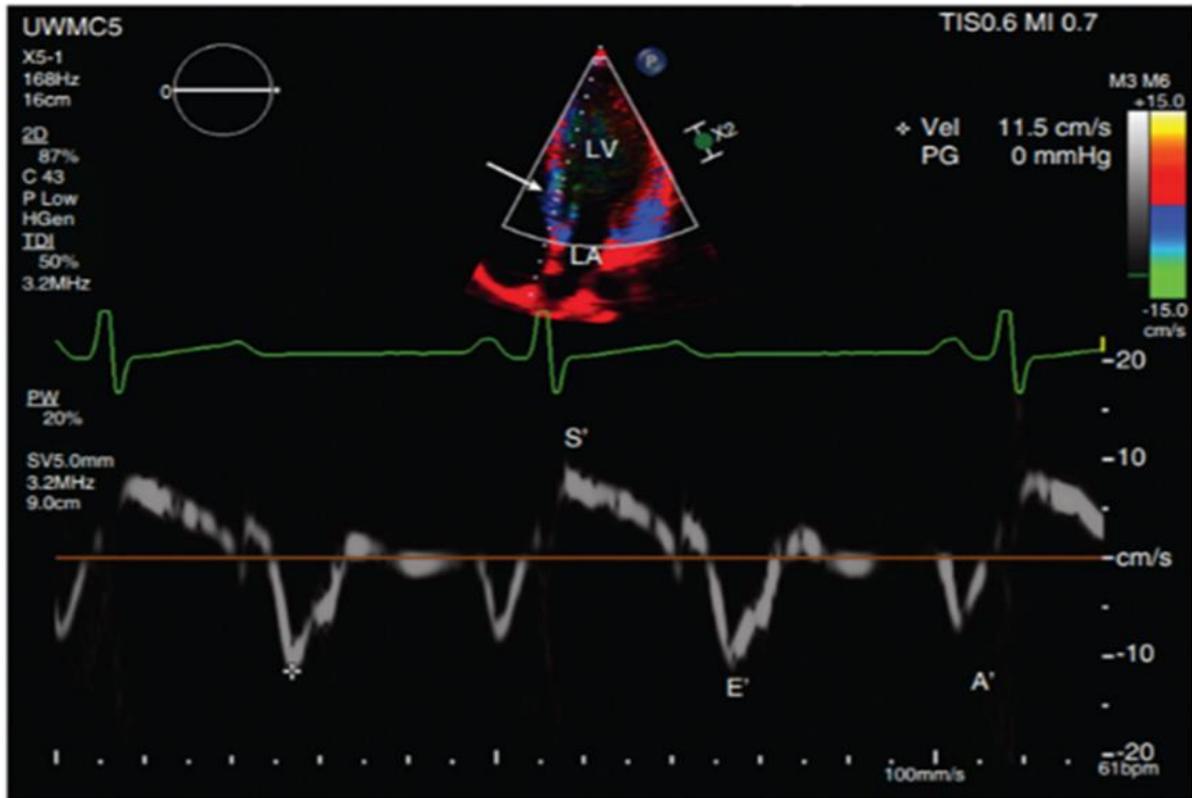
Mitral annulus in the septal wall and lateral wall peak tissue velocities in systole (S') as well as early (E') and late/atrial (A') diastole. (Echocardiography textbook).
